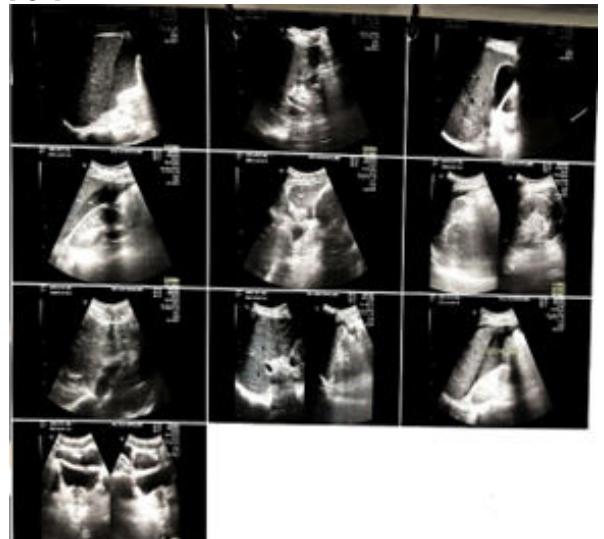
Ultrasonography of the abdomen showing moderate fluid collection and internal echoes
